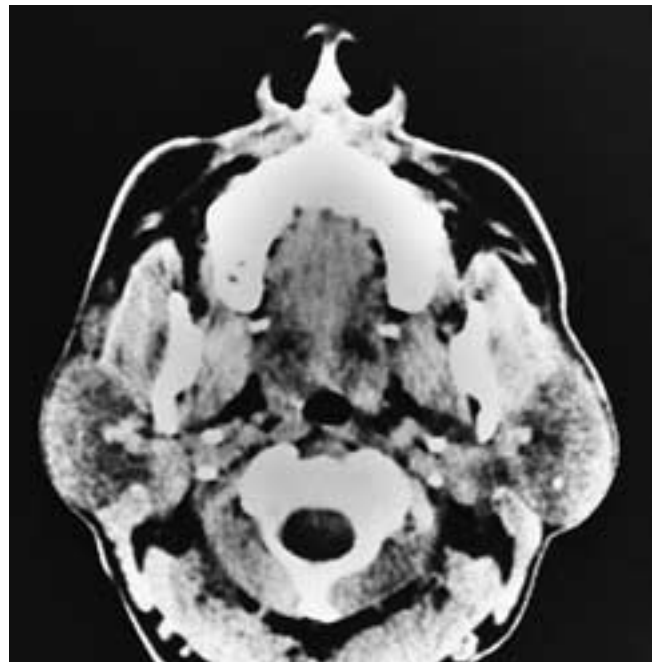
Axial contrast-enhanced CT scan shows larger and slightly denser parotid glands than normal. This is a nonspecific finding, and this patient had early autoimmune disease.
